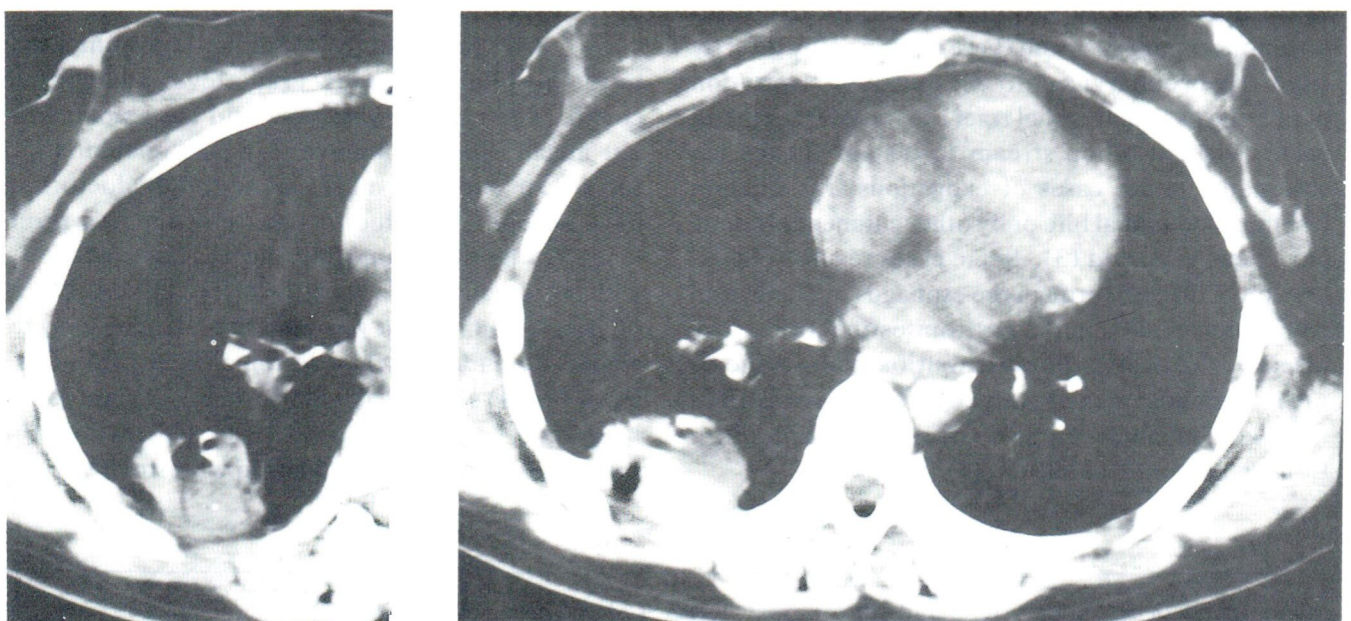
CT scan of the thorax at the lesion of right lower lobe, using mediastinal window showed a mass like lesion with small eccentric cavities.
